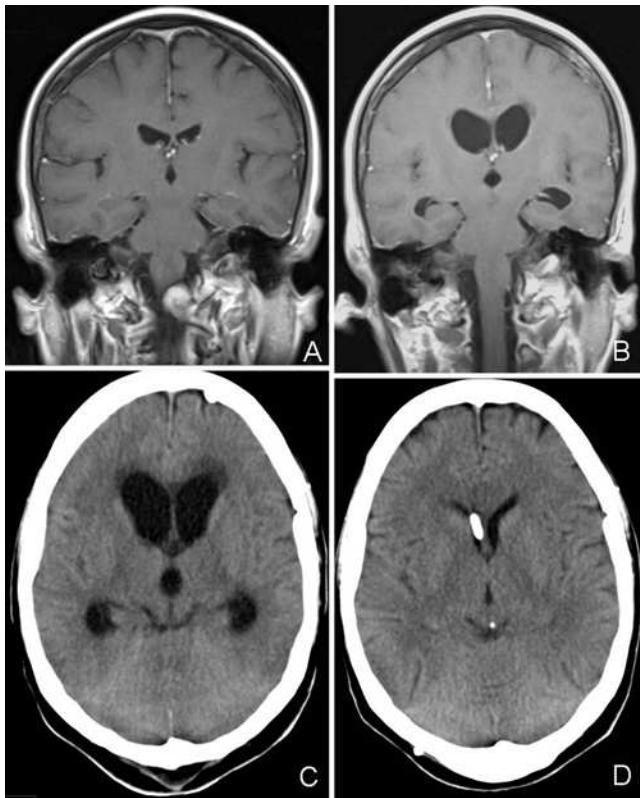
A: Preoperative MR image. B: Postoperative MRI after meningioma removal. C: Axial CT scan demonstrating hydrocephalus 2 months after meningioma surgery. D: Axial CT scan after shunt insertion.
